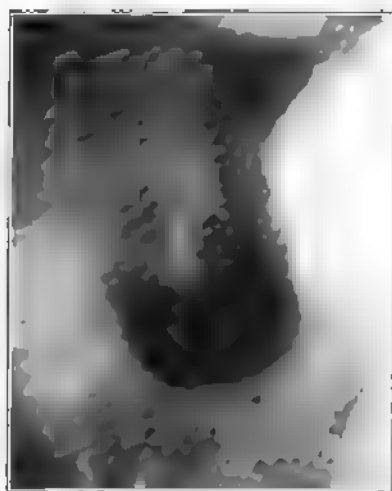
(A88,115, X-ray 20,799.) A. C., female, aged sixty-two. Radiogram shows "fish hook" stomach with a moderately large projection on the lesser curvature which was regarded as perforating ulcer. No transverse contraction seen. Small residue after six hours. Operation: Resection one-half middle of stomach; end-to-end union. Pathologic report: Carcinomatous ulcer with glandular involvement.
